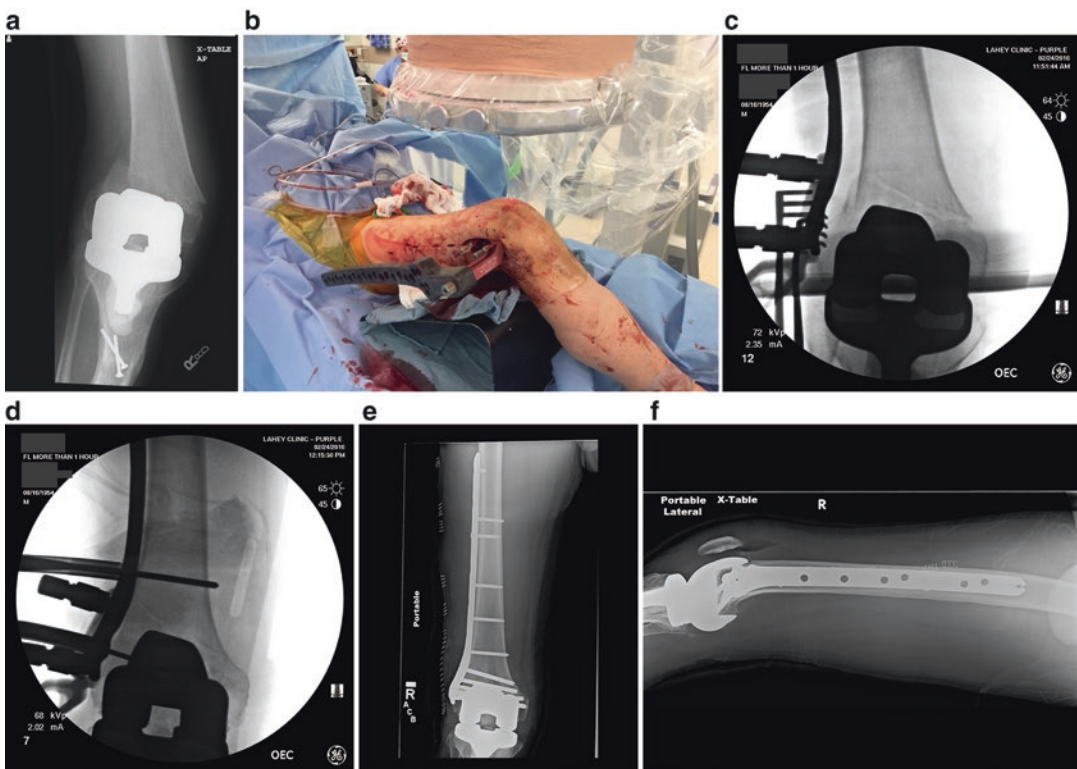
Case example of a 65-year-old male with a periprosthetic distal femur fracture above total knee treated with a distal femoral locking plate using submuscular insertion technique. The injury AP (a) radiograph shows a distal femoral fracture above the femoral component with an intact femoral component. (b) Using the submuscular technique is aided by the use of a radiolucent jig
